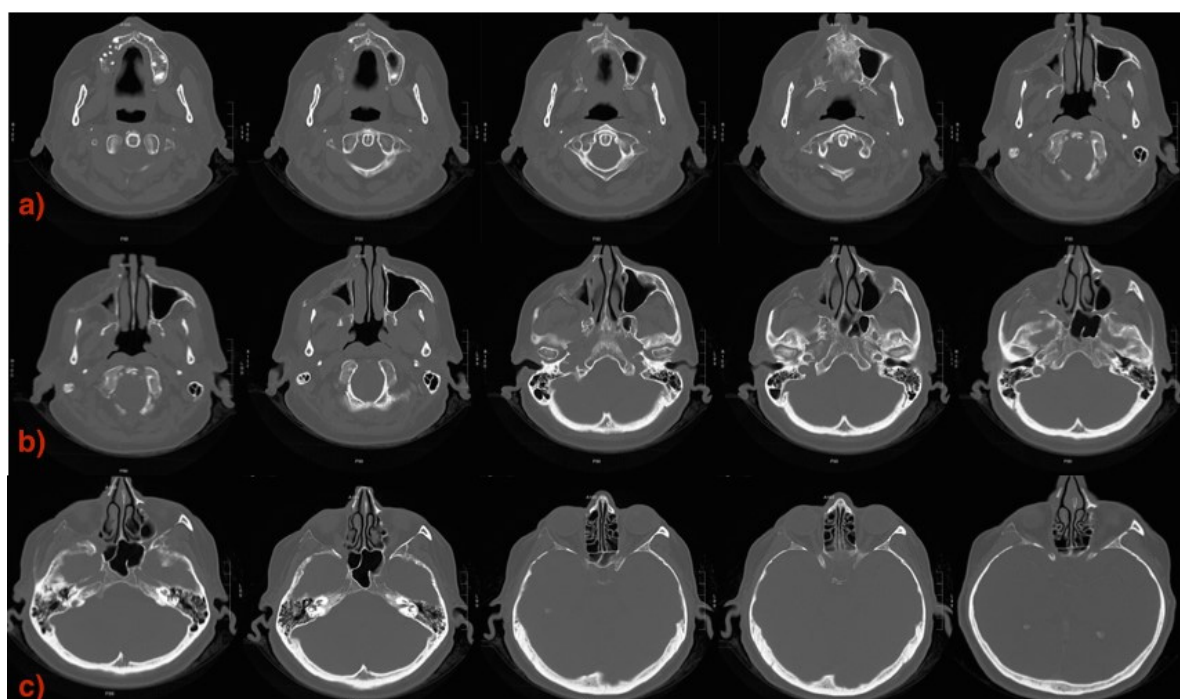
CT. a) Osteolytic alteration in the right maxillary region, characterized by erosion of the alveolar bone and palate. b) Asymmetric expansion of the maxillary sinus for a collapse of the right maxillary sinus. Osteolytic alteration of the zygomatic arch, close to the zygomatic process of the frontal right bone. c) Osteolytic alteration with erosion of the right lateral area of the orbit and sinking of the orbital floor due to the collapse of the maxillary sinus; osteolytic alteration involved the right orbital process of the frontal bone and diploe.
